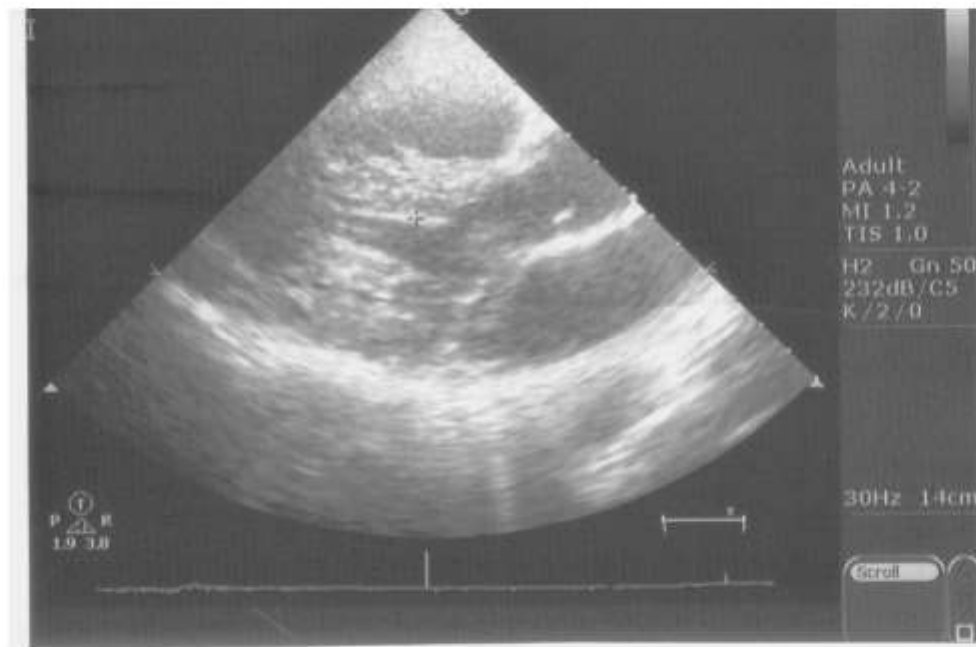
Echocardiogram. Parasternal, long-axis view of case 3, demonstrating the accessory papillary muscle just below the interventricular septum.
